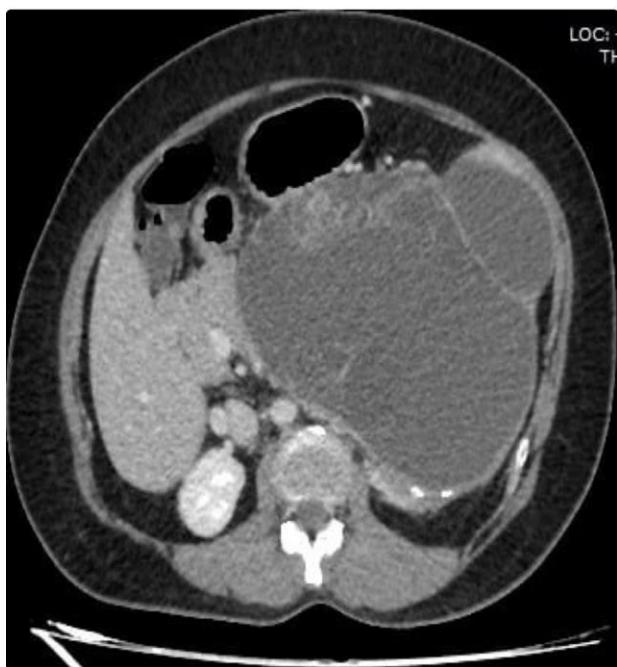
Contrast enhanced CT scan of abdomen showing large multilocystic lesion in the spleen, displacing surrounding organs like the pancreas and aorta.
